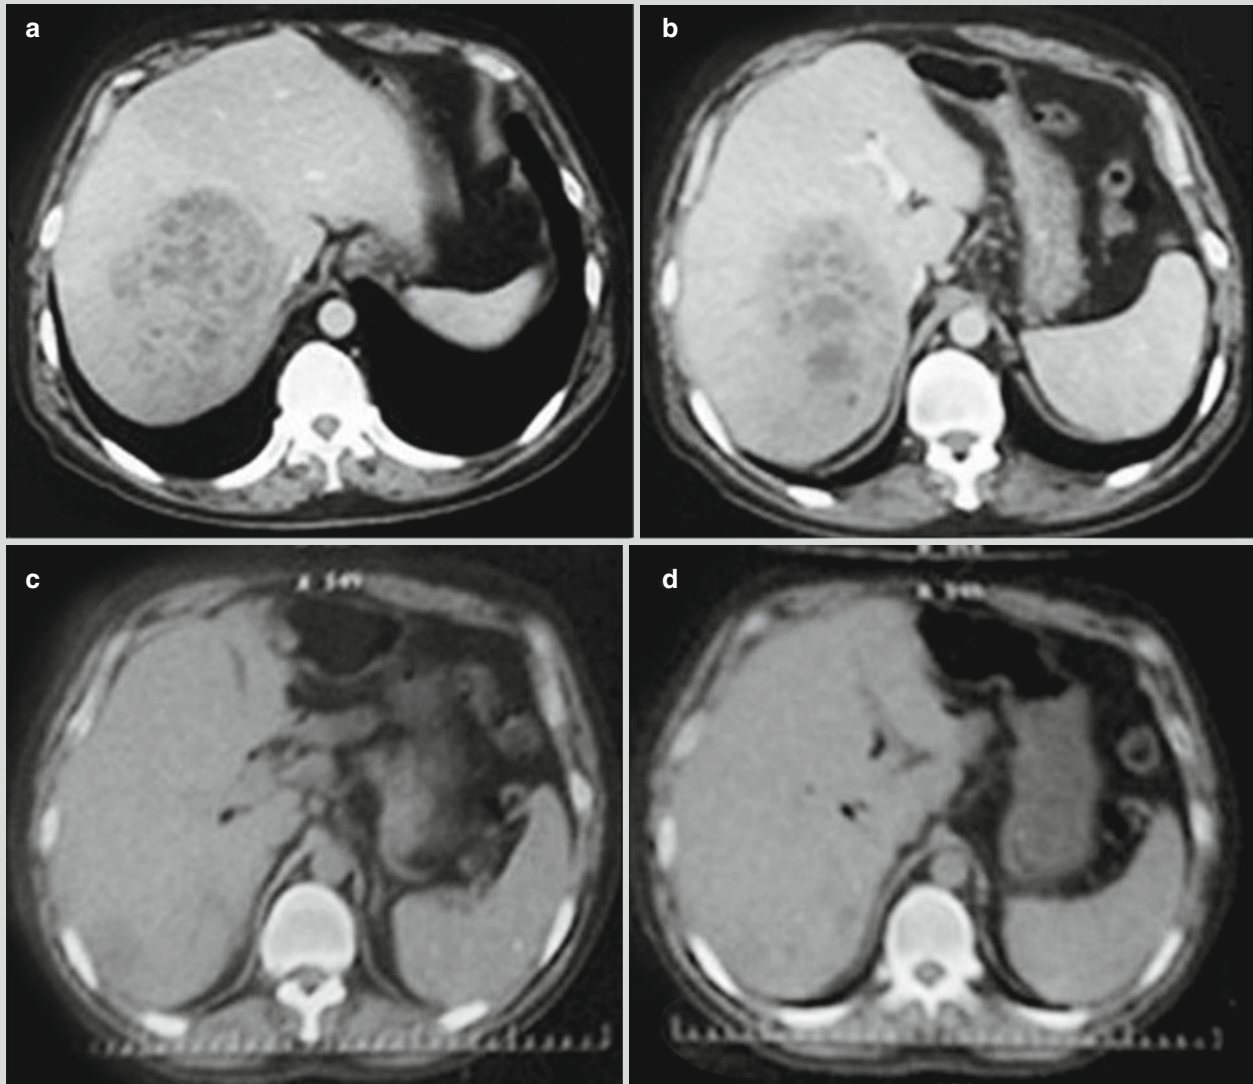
Hepatic lesions of visceral leishmaniasis. (a, b) CT scanning demonstrates large flakes of honeycomb-like low-density shadow in the right hepatic lobe, with quite clearly defined boundaries and uneven inner density. Contrast CT scanning demonstrates
